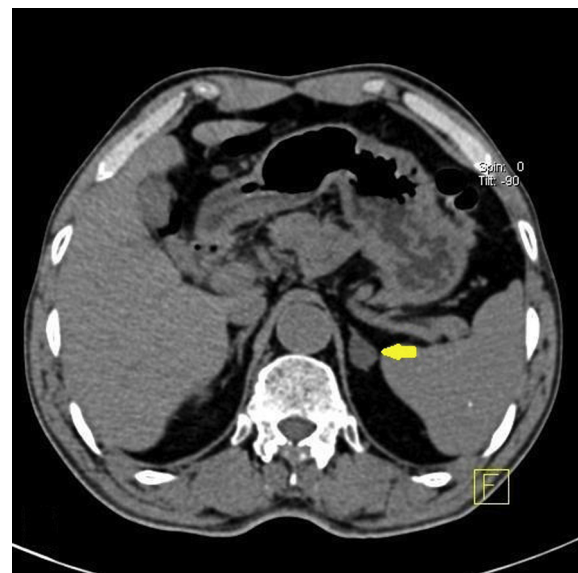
Thirty-four year old male patient with bilateral flank pain. In addition to bilateral renal stones, CT stone protocol shows a left adrenal lipid-rich adenoma (arrow).
